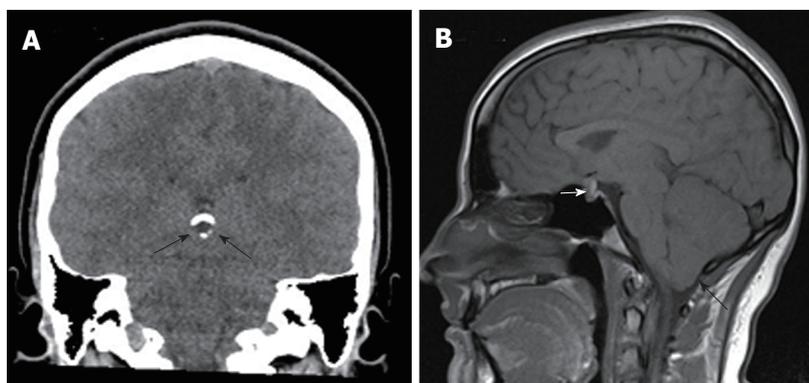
Three out of four incidental findings in a single 16-year-old girl who presented with right facial nerve palsy. The left maxillary sinusitis is not shown. A: Coronal non-contrasted computerized tomography of the brain shows a partially calcified cystic pineal lesion (black arrows); B: A true midline sagittal magnetic resonance image contrast enhancing pituitary mass measuring 13 mm × 10 mm × 10 mm (white arrow) and cerebellar ectopia, 7 mm (black arrow). There was no enhancement of facial nerve in vicinity of the right internal carotid canal.
